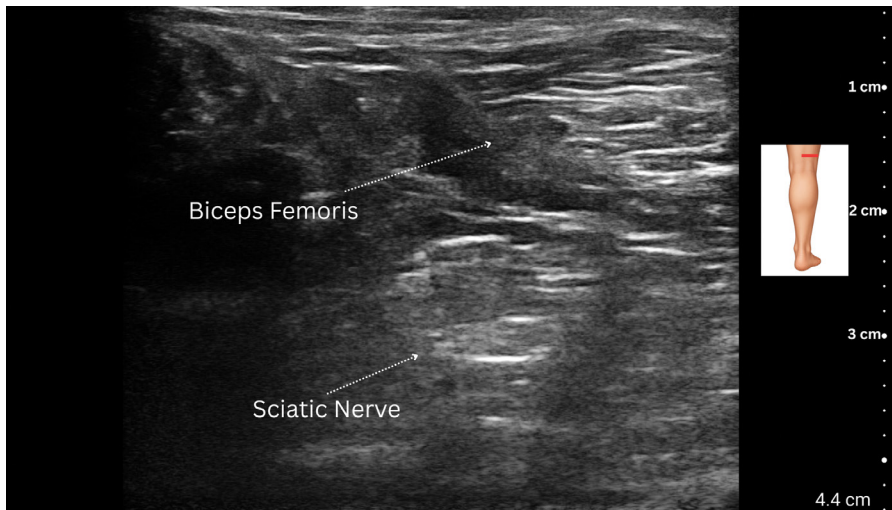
Transverse ultrasound scan at the level of the distal posterior thigh, just before the sciatic nerve bifurcation. The sciatic nerve sits near the short and long head of the biceps femoris muscle.
